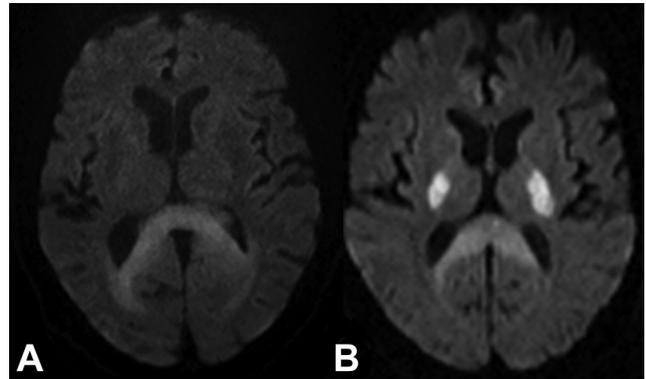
Examples of two patients with Marchiafava-Bignami disease. A) and B) DWI shows symmetrical boomerang-shaped diffusion restricted lesions in the splenium of the corpus callosum. B) Note additional symmetrical diffusion restricted lesions in the corona radiata.
